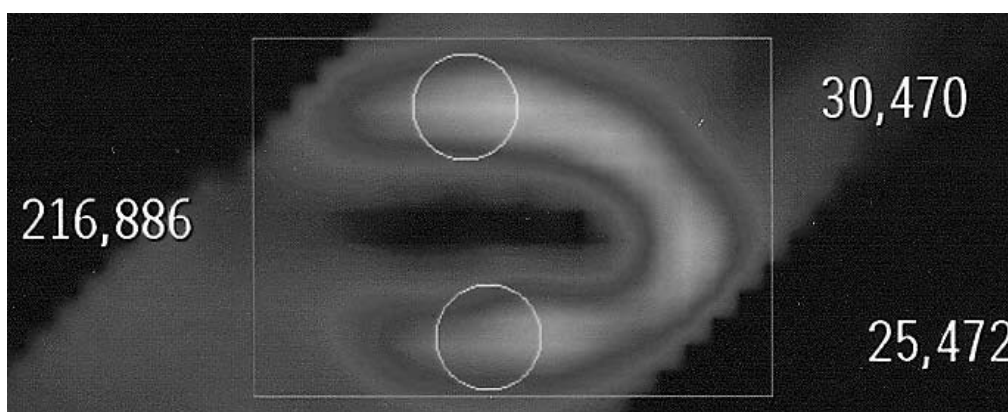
SPECT image acquired 60 minutes post stress with regions of interest including the total heart, anterior and inferior myocardial regions.
